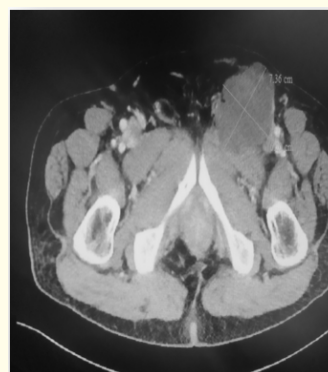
Computed tomography image of the left inguinal lymphadenopathy.
